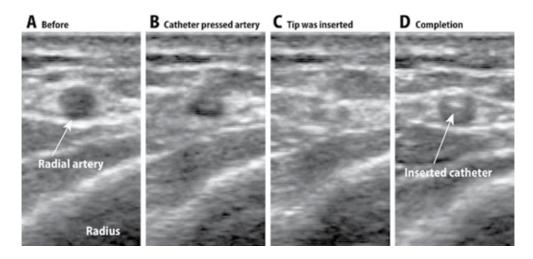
Representative series of four ultrasound images obtained during insertion of a radial artery catheter. A:before catheter insersion, B and C :during catheter insertion, D:completion of catheter insertion
